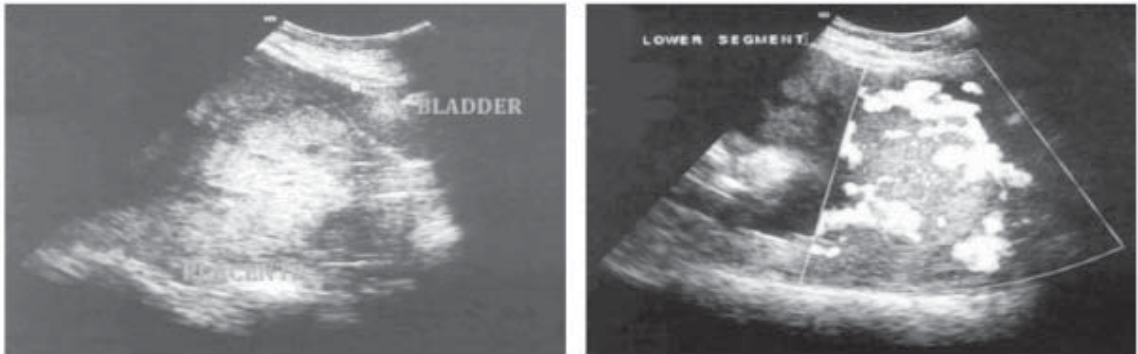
Ultrasound features suspicious for placenta accreta include a) obliteration of retroplacental clear space , b) turbulent blood flow between placenta and bladder
